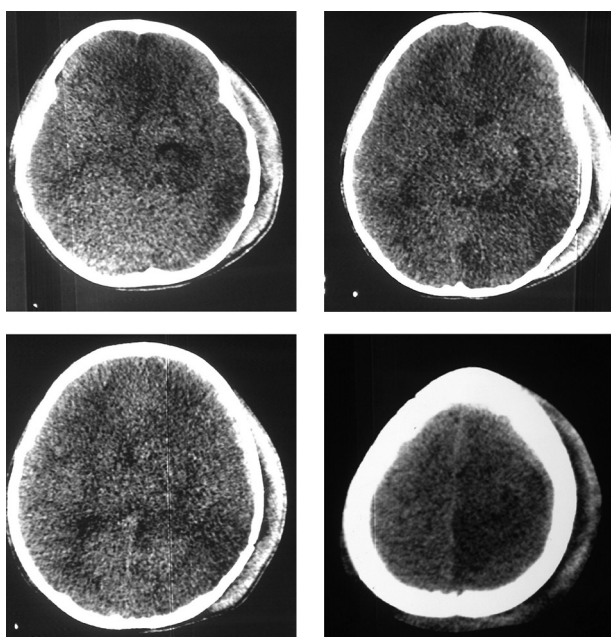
Brain Computed Tomography on the Second Day of Admission Showing Ischemia
